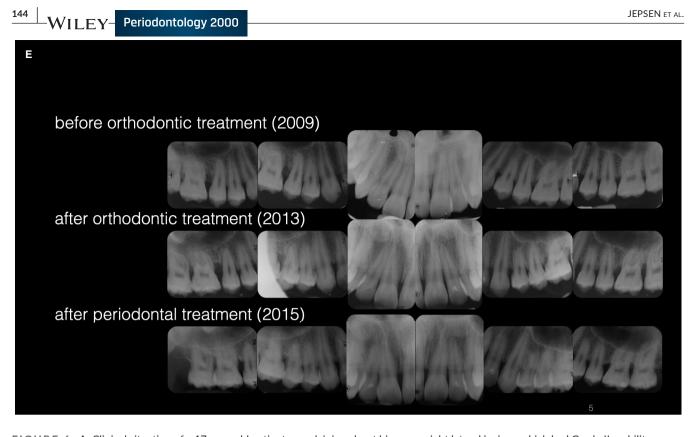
A, Clinical situation of a 17-year-old patient complaining about his upper right lateral incisor, which had Grade II mobility, bleeding of his gums, and food impaction. His orthodontic therapy had just reached completion, and his primary concern was losing all his teeth. He presented with a good level of oral hygiene, with a plaque index (PI) of 21% but a high full-mouth bleeding on probing (BOP) score of 51%. The diagnosis was periodontitis stage III, grade C (Photographs–Courtesy of Ph. Skora). B, Radiographs of the patient showing distinct bone loss on all first molars. C, Clinical situation, 5 years later, of the now 22-year-old patient after comprehensive periodontal treatment including steps 1–3 of therapy and a strict maintenance program. D, Over the course of active periodontal treatment and maintenance the patient could be kept stable with plaque and bleeding on probing scores decreasing to below 10%. E, Comparison of radiographs taken before and after orthodontic treatment and following comprehensive periodontal therapy. Distinct bone loss on the maxillary right first molar was already visible before tooth movement, and bone loss was present on all first molars 4 years later.
